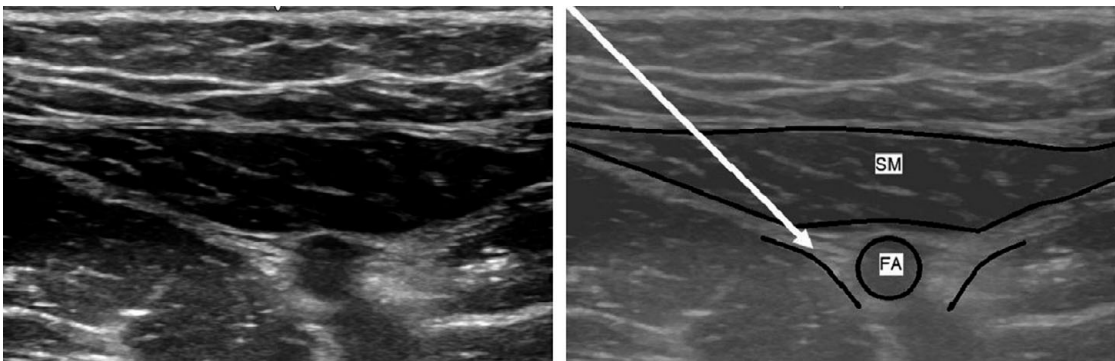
Ultrasound appearance of the adductor canal, showing sartorius muscle (SM) and the femoral artery (FA).
